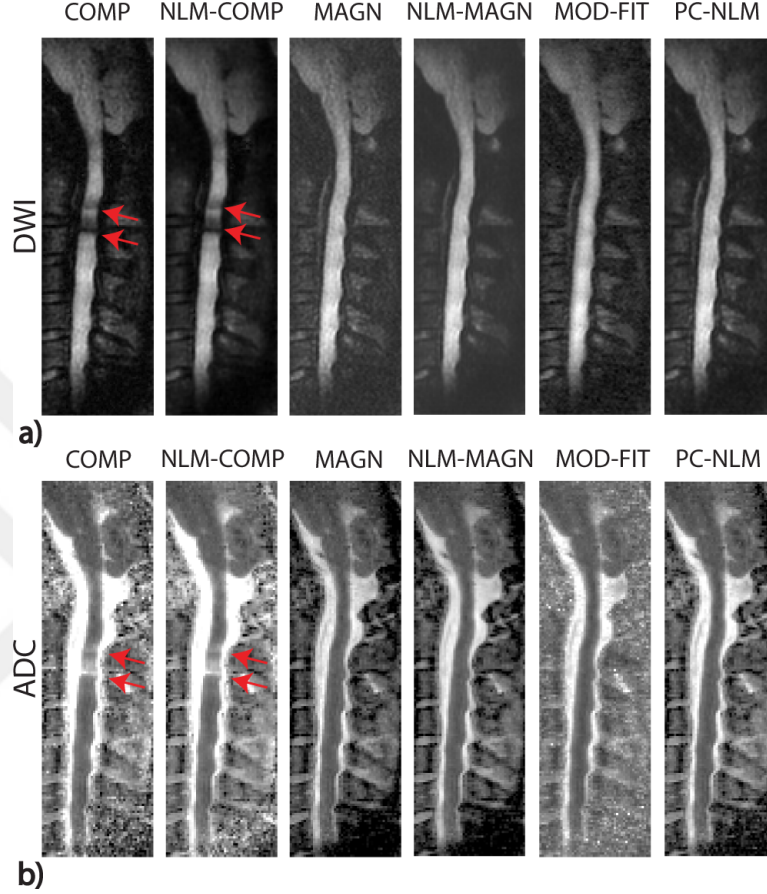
Reconstructions from in vivo DTI acquisitions of the spinal cord for the second subject. Images with diffusion-encoding along the A/P direction are displayed. a) DWI images are shown for the proposed PC-NLM and alternative reconstructions. Note the suppressed noise level and the lack of signal cancellations with the proposed reconstruction. b) The corresponding ADC maps.
